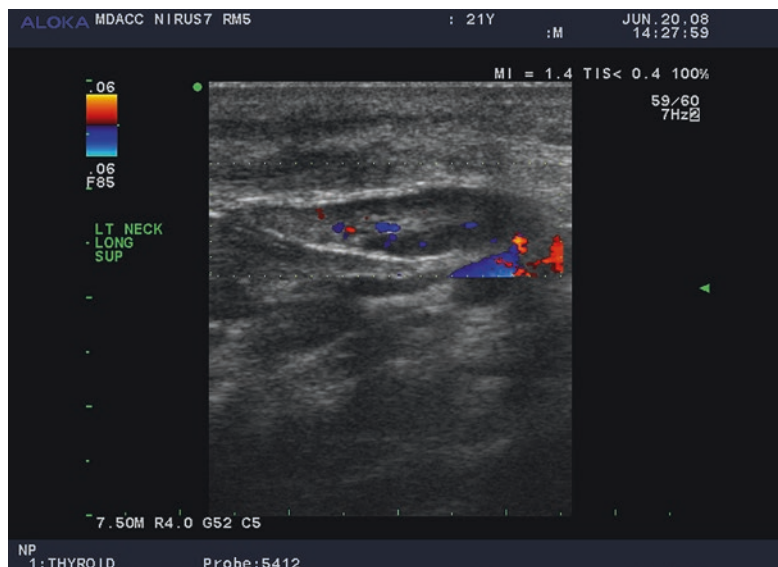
Doppler ultrasound imaging of a normal cervical lymph node. The echogenic line at the top of the image represents the dermis. The lymph node demonstrates normal cortex with relatively decreased echogenicity compared to the hilum. The red and blue colors indicate normal blood flow in opposite directions, contained within the hilum
